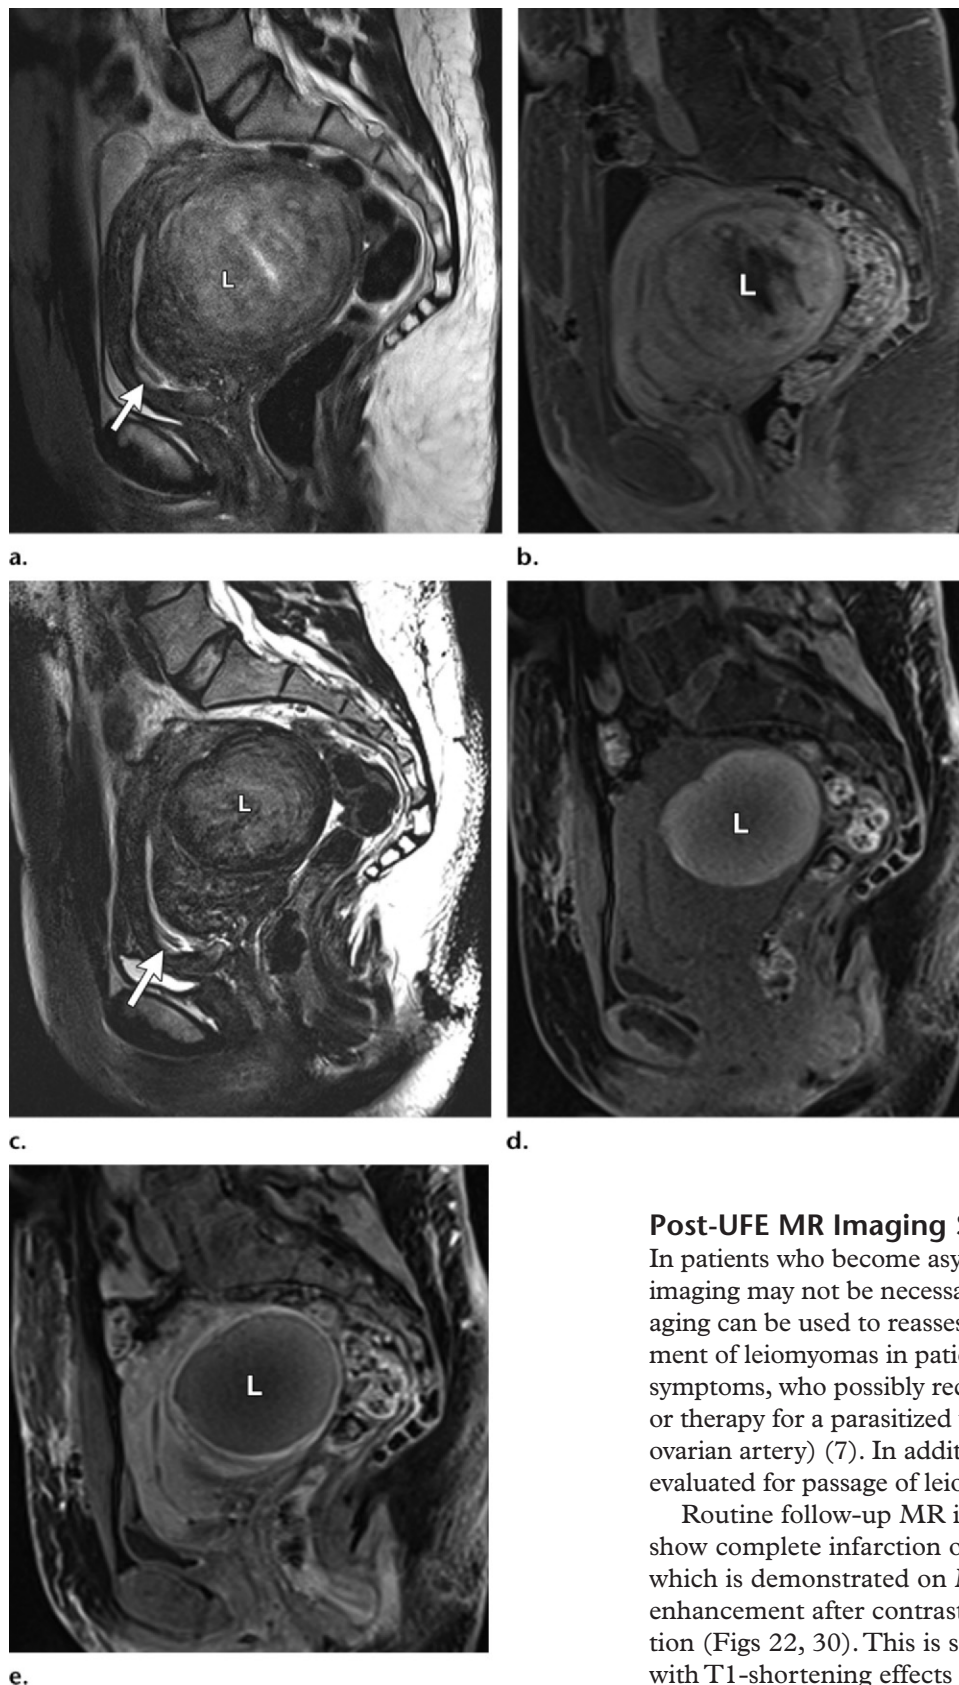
Complete coagulative necrosis. (a, b) Sagittal T2-weighted (a) and contrast-enhanced fat-suppressed T1-weighted GRE (b) images before UFE show a viable intramural leiomyoma (L) in the posterior fundus. (c–e) Sagittal T2-weighted (c) and nonenhanced (d) and contrast-enhanced (e) fat-suppressed T1-weighted GRE images after UFE show complete coagulative necrosis of the leiomyoma (L) without residual viable tissue. Also note the small incidental lower uterine segment polyp protruding into the endocervical canal (arrow in a and c). (Case courtesy of Susan M. Ascher, MD, Georgetown University Hospital, Washington, DC.)
